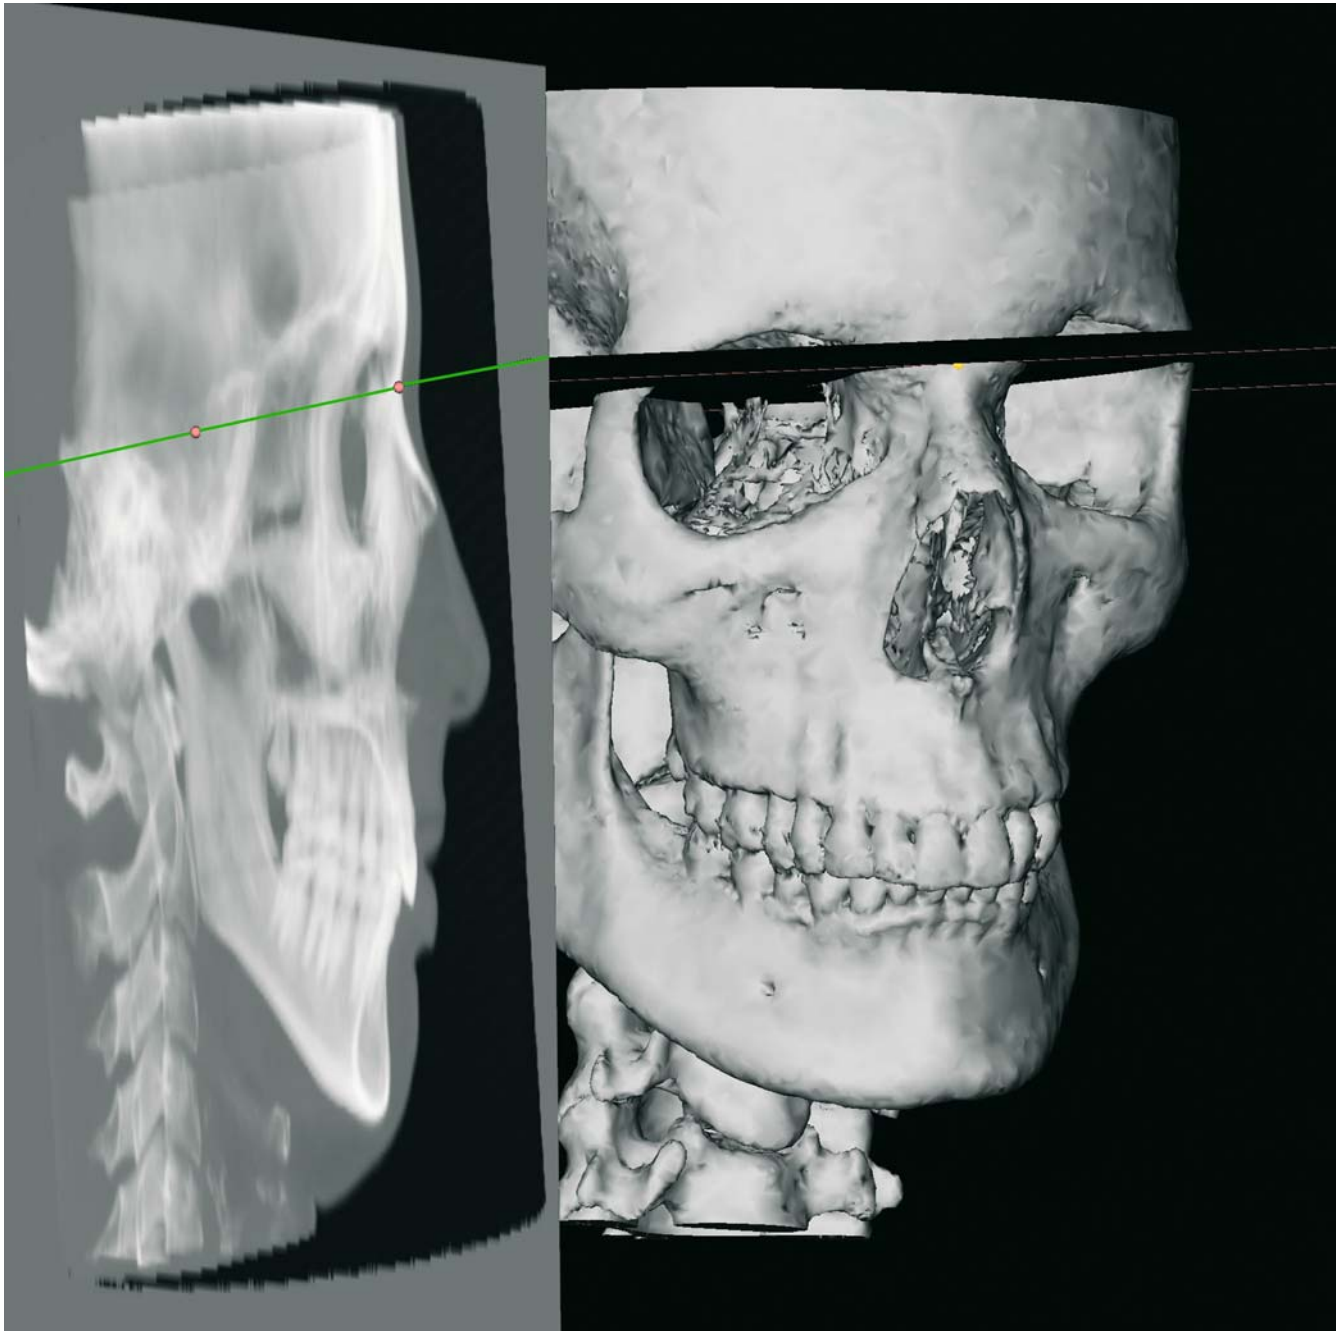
Anterior cranial base (S-N) plane. Virtual lateral cephalogram linked to the 3-D hard tissue surface representation (3-D CT, patient K.C.)
